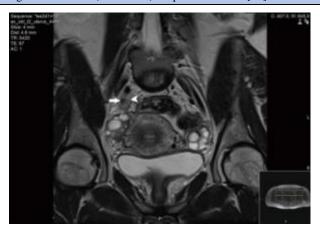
Magnetic resonance imaging (MRI) scan of the pelvis showing abnormal tissue (arrowhead) which encases the right distal ureter (arrow). Reproduced from: [57] Under the Creative Commons Attribution License.
